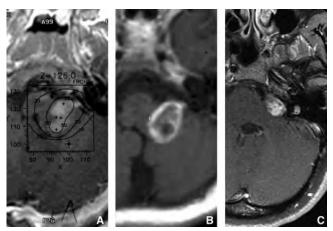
The initial radiosurgical MRI scan of a 4-year-old child with a residual pontine exophytic juvenile pilocytic astrocytoma (*A*). Six months later, the tumor shows central necrosis and slight enlargement (*B*). At 10 years, the tumor has regressed (C).
